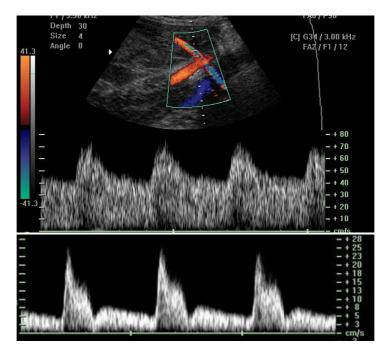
Doppler spectra of uterine artery flow. The color flow image allows beam / flow angle visualization. The sonogram on the top shows high velocities throughout the cardiac cycle, indicating low distal resistance. The sonogram at the bottom shows a pulsatile flow waveform with low diastolic velocities; this is indicative of high distal resistance.
